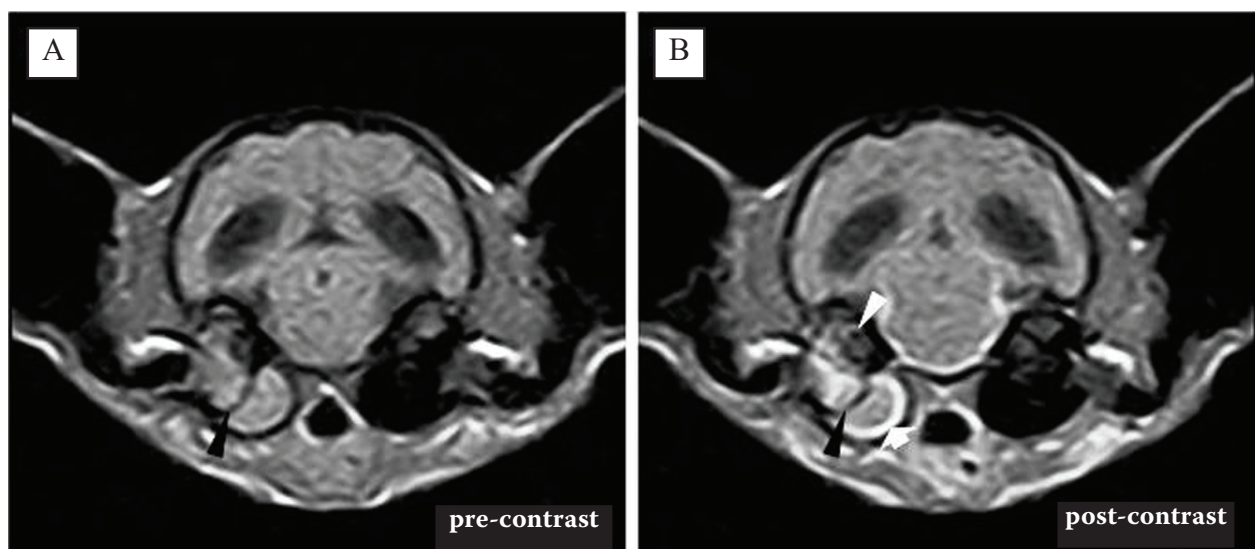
Magnetic resonance imaging at the level of the tympanic bulla. The bony septum dividing the tympanic cavity is well-defined (black arrow head). (A) Pre-contrast transverse T1-weighted spin echo image (repetition time (TR) = 870 ms, echo time (TE) = 18 ms). There is a sharply-demarcated mass with intensity comparable to brain tissue and subtle hyper-intensity in the middle of the dorsolateral compartment. (B) Post-contrast transverse T1-weighted spin echo image (TR = 870 ms, TE = 18 ms). There is a non-uniform enhancement of mass in the dorsolateral compartment and a rim of increased signal intensity in the ventromedial compartment of the tympanic bulla (white arrow). Moreover, a contrast-enhancement is evident with a slightly increased signal intensity in the area of the membranous labyrinth (white arrow head)
